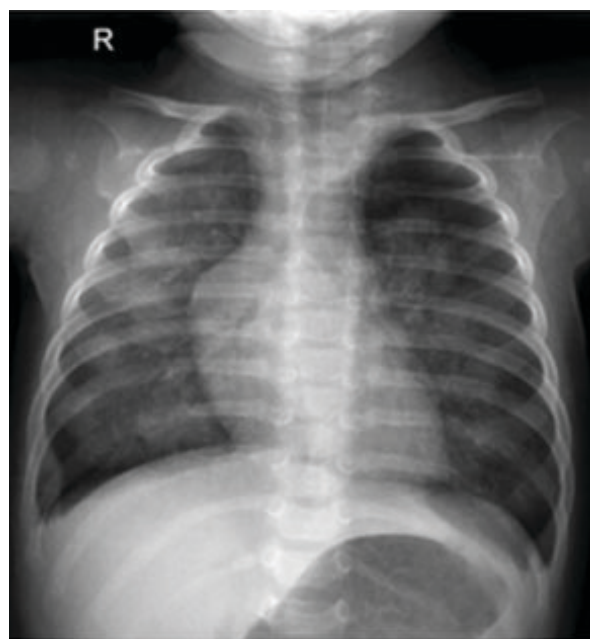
Chest X-ray showed diffuse haziness with air bronchogram on both lung fields.
